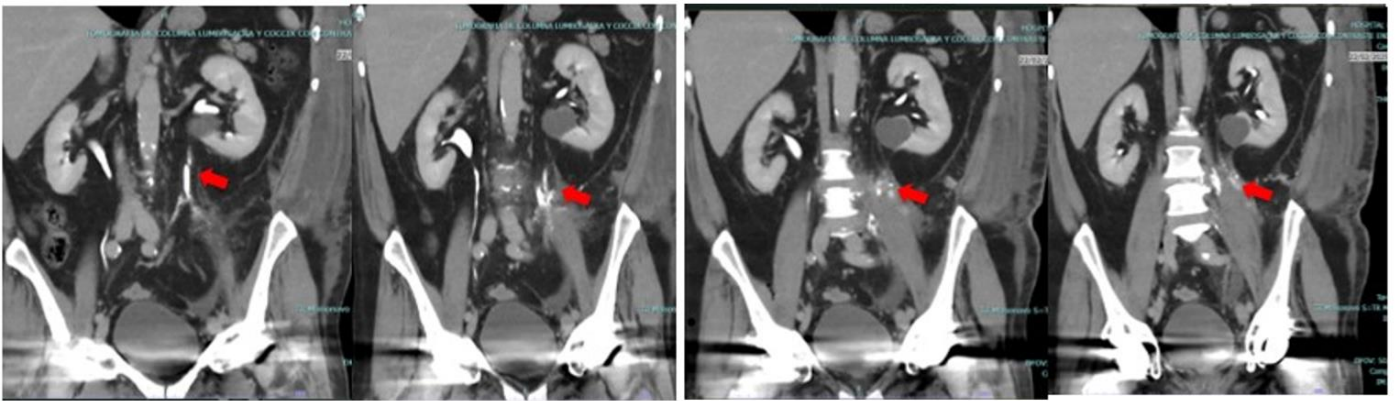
Contrast-enhanced abdominal and pelvic CT scan. In the coronal views, the red arrow indicates the location of the ureteral injury and the contrast extravasation
